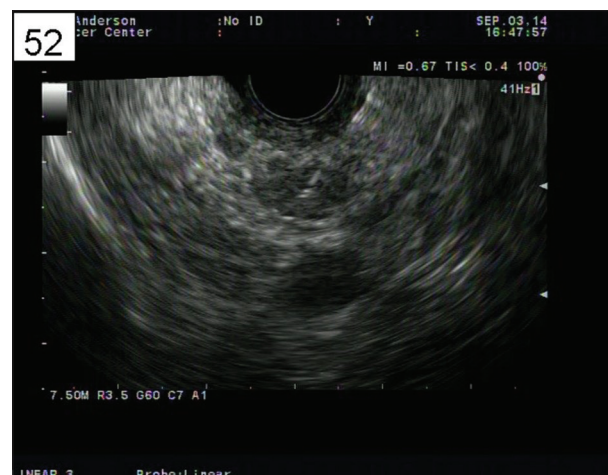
Endoscopic ultrasound image showing transduodenal endoscopic fine needle aspiration of the pancreatic nodule with a 25-gauge needle
